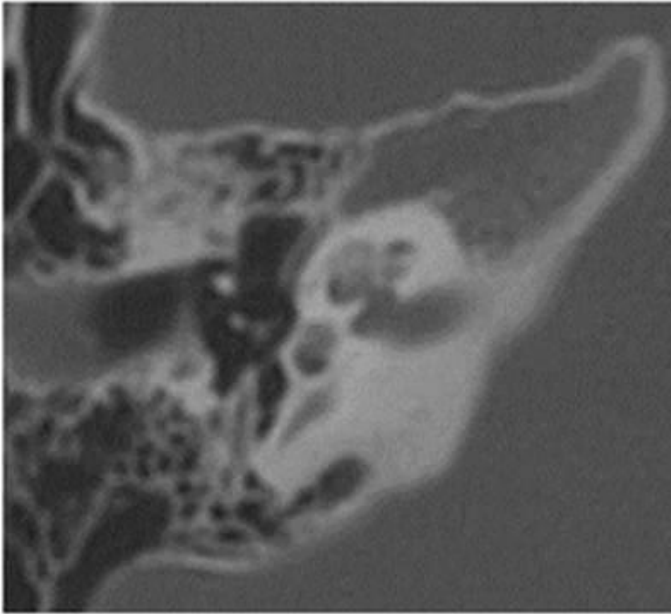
LAMM syndrome (A) CT scan. Second bend and vertical tract of the right facial nerve. (B) CT scan. On the both sides are evident hypoplasia of incus and aplasia of staple. (C) CT scan. First and second intracanalicular tract of facial nerve.(D) CT scan. Left facial nerve's canal. (E) MRI. Evident facial nerves (arrows), not evident acoustic nerves on the both sides. The left internal auditory canal is hypoplastic, while the right is aplastic. Bilateral absence of the membranous labyrinth's signal. (F) CT scan. Remarkable hypoplasia of the left internal auditory. (G) MRI. Sagittal oblique scan: evident the intracisternal tract of the left facial nerve (arrow) [49].
